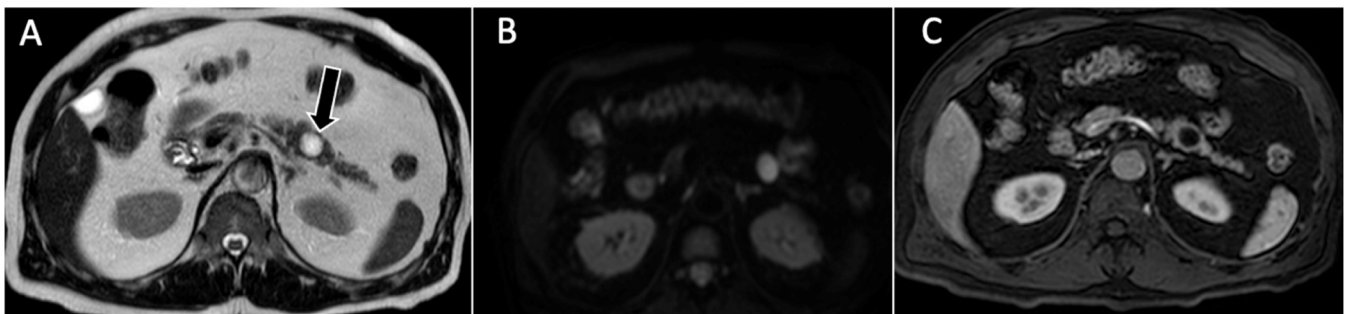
63-year-old man with cystic pancreatic neuroendocrine tumor. A. T2-weighted non-fat sat sequence in the axial plane shows a uniloculated cyst (arrow), with lack of septa. B. On diffusion-weighted-image the lesion shows diffusion restriction. C. On contrast-enhanced T1-weighted MR image a thin enhancing wall is evident.
